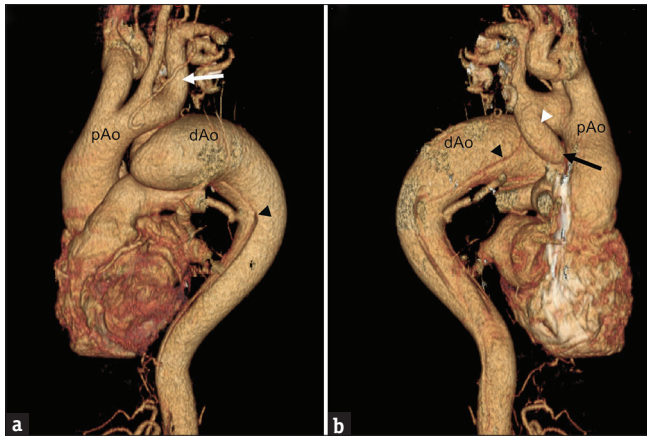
Three-dimensional reconstruction of a computed tomography angiography. (a) Anterior view shows a Stanford type B aortic dissection (black arrowhead) with obvious anomaly of aortic arch. The aortic arch is seemingly interrupted in the middle and divided into proximal and distal portion after bifurcation of left subclavian artery (white arrow). The distal portion of the arch enlarges to a bulbous aneurysm. (b) Posterior view demonstrates a downward curving tubular hypoplasia (white arrowhead) which arises from the proximal portion of the aortic arch and funnels down toward the discrete coarctation (black arrow). The dissection shows the intimal flap originated from the distal portion of aortic arch (black arrowhead)
